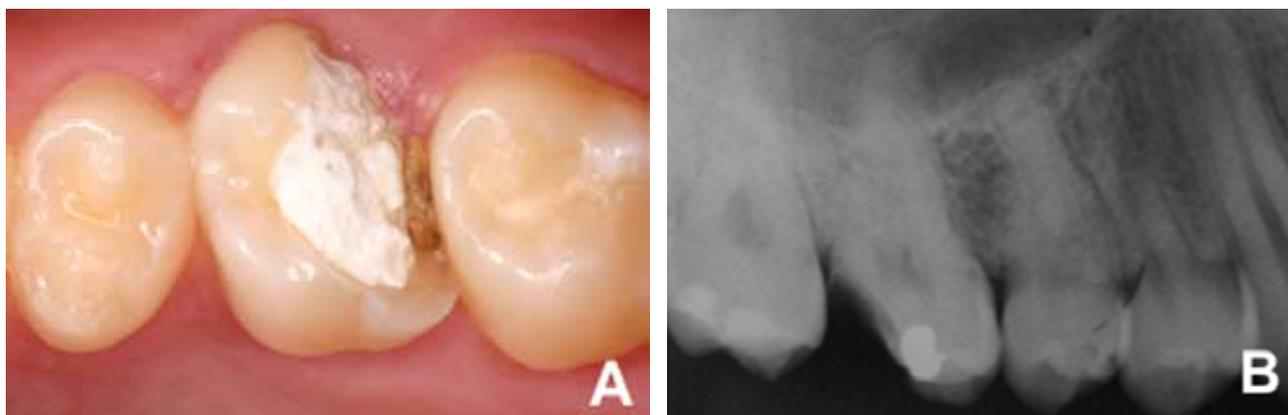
Initial clinical and radiographic examination of tooth 16. A - Radiographic image of the crown-root fracture. B - Radiographic image.
